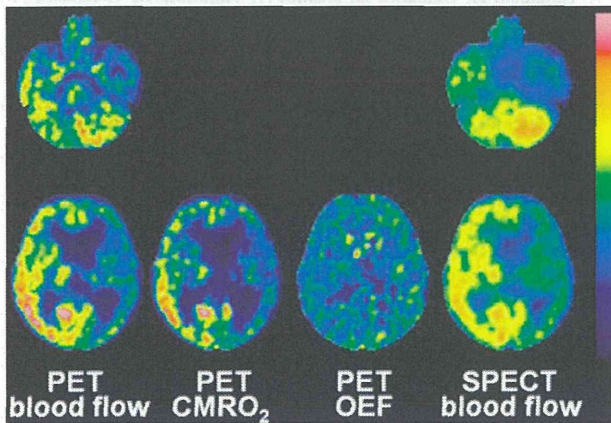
A 52-year-old man with symptomatic occlusion of the right ICA. The degree of blood flow asymmetry on PET is considerably greater in the MCA territory than in the cerebellar hemisphere.  $CMRO_2$  asymmetry in the MCA territory is not observed and OEF asymmetry in the MCA territory is evident on PET. While blood flow asymmetry in the MCA territory is evident on SPECT, blood flow asymmetry in the cerebellar hemisphere is not observed on SPECT
